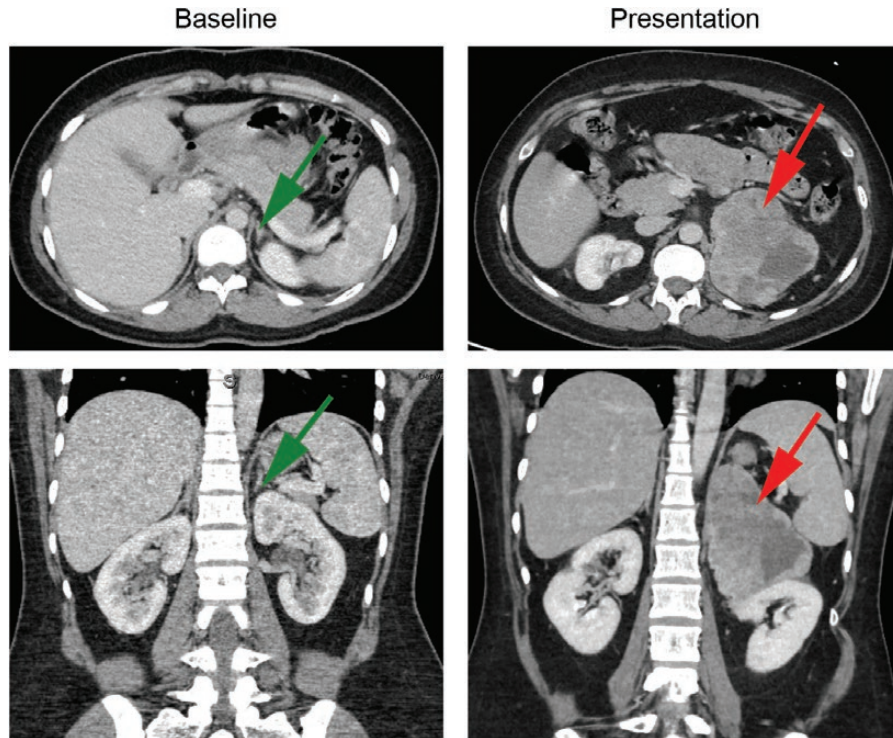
The abdominal computed tomography (CT) of the patient at baseline and at presentation only 8 months later revealing a large (10.1 x 7.9 x 10.8 cm) heterogeneous left adrenal mass. Green arrow shows normal adrenal gland; Red arrow shows large ACC mass.
